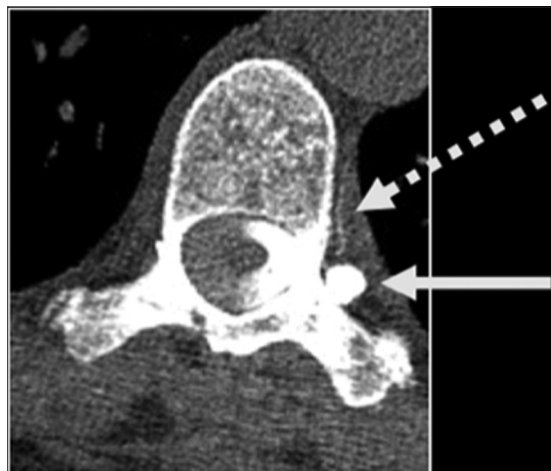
Case 3. Axial CT Myelogram demonstrates a left T9-T10 spinal meningeal diverticulum (solid arrow) and opacification of an adjacent left paraspinous vein (dotted arrow), suspicious for a CSF-venous fistula.
